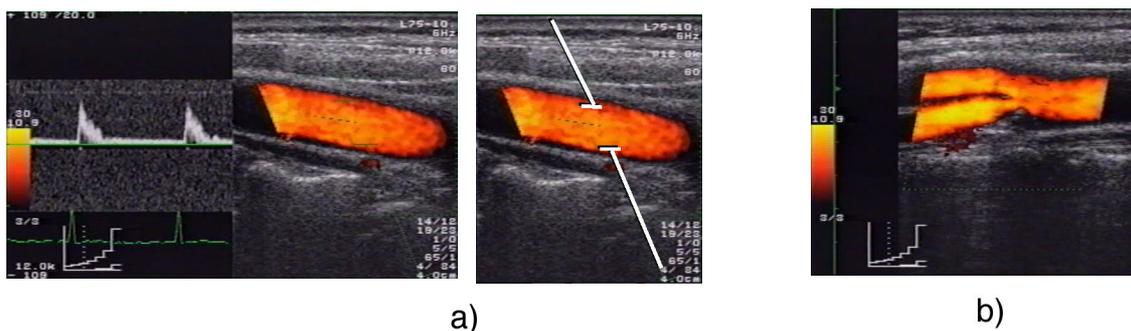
Velocity Measurement and Power Doppler
